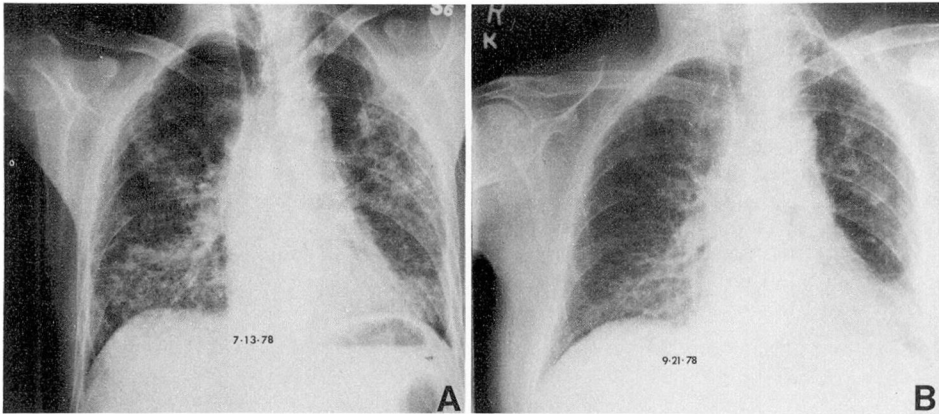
A, Posteroanterior chest roentgenograms showing bilateral interstitial infiltrates at start of treatment. B, Marked clearing after therapy.
